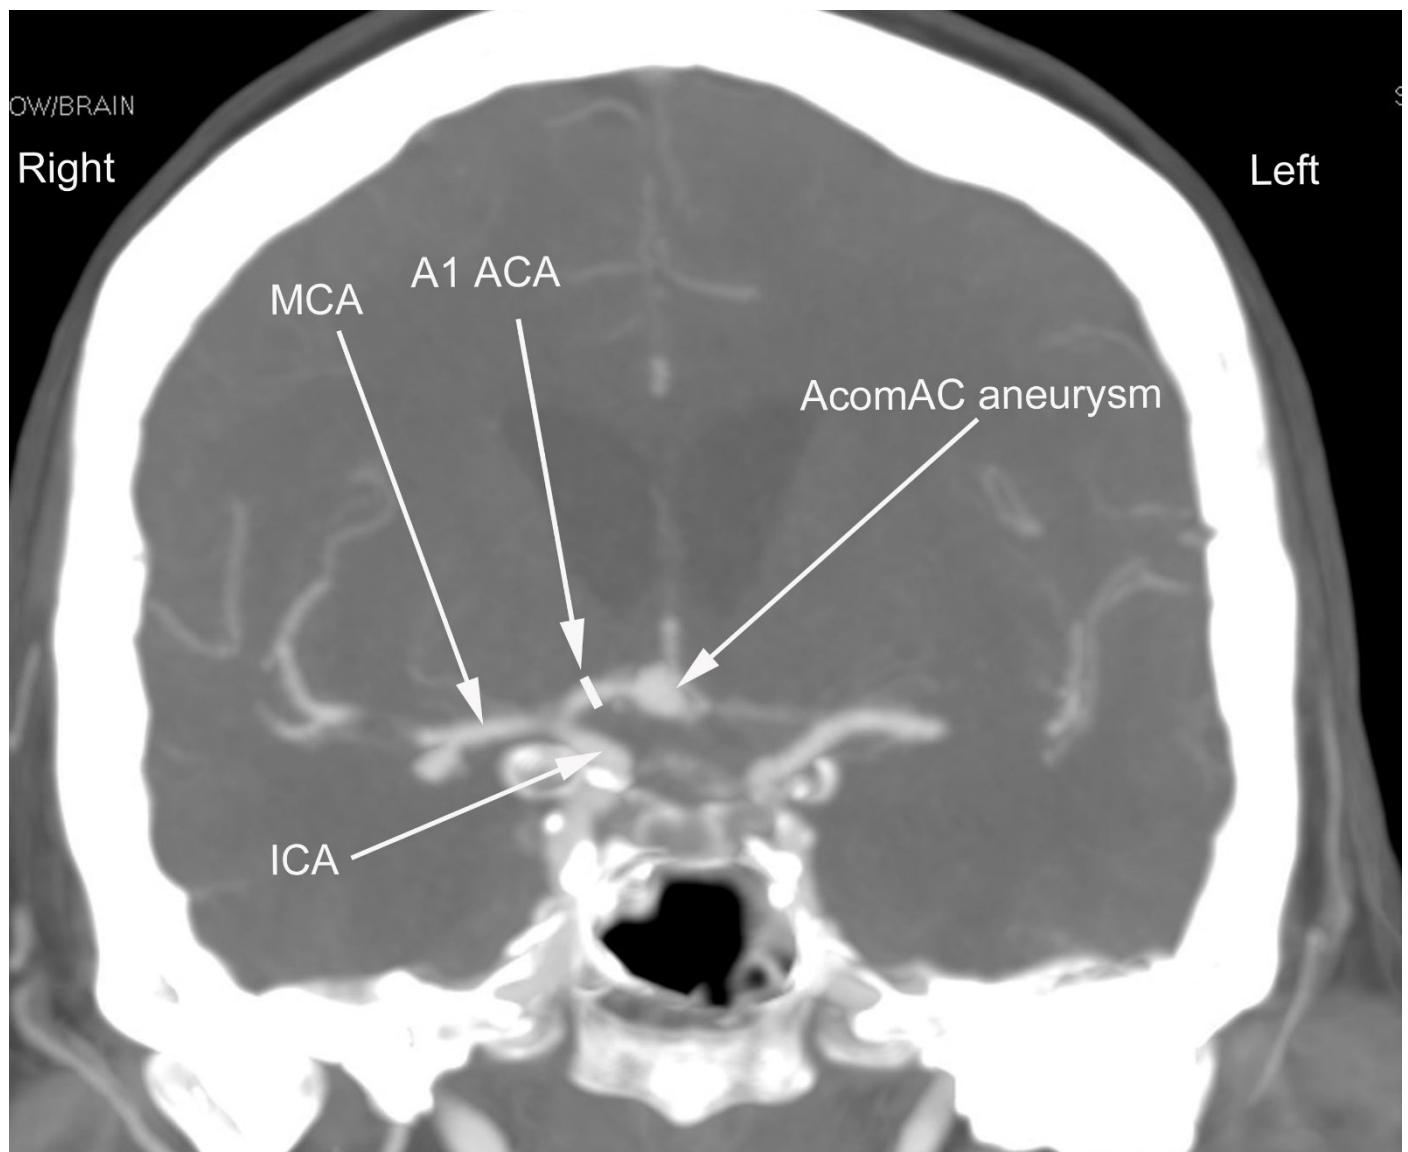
Cerebral Computed Tomography Angiography (CTA) scan with AcomAC aneurysm in coronal view, white line perpendicular to the long axis of the vessel (A1 ACA) indicates measurement site. A1 ACA = the first part of anterior cerebral artery; MCA = middle cerebral artery; ICA = internal carotid artery, and AcomAC = anterior communicating arterial complex.
